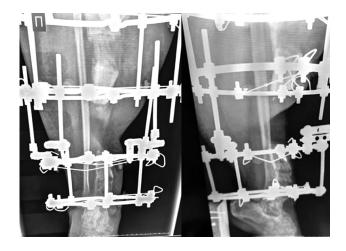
Radiographs of the patient's M tibia in the course of treatment
